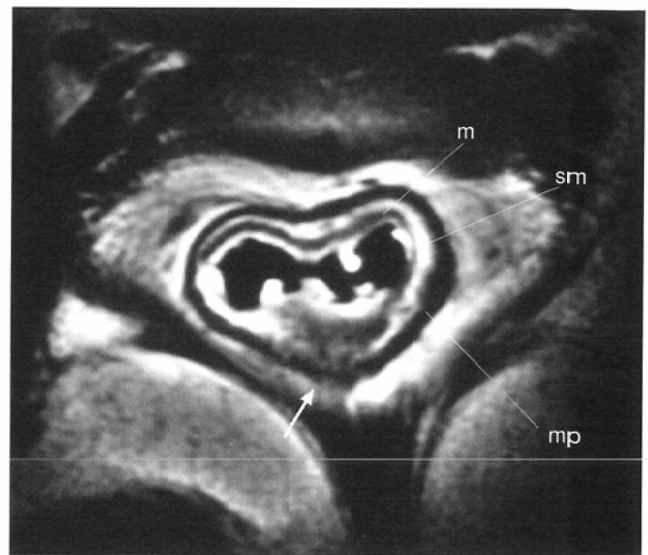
In some cases (4/55), the submucosa (sm) appears very bright between the dark mucosa (m) and muscle layer (mp) on noncontrast T1-weighted images, providing natural contrast. A tumor located at the posterior wall infiltrates the submucosa and superficial muscle layer (arrow).
